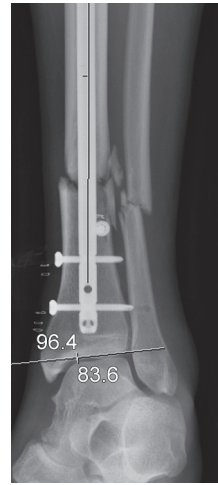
An AP radiograph taken immediately postoperative with the joint angle measured
